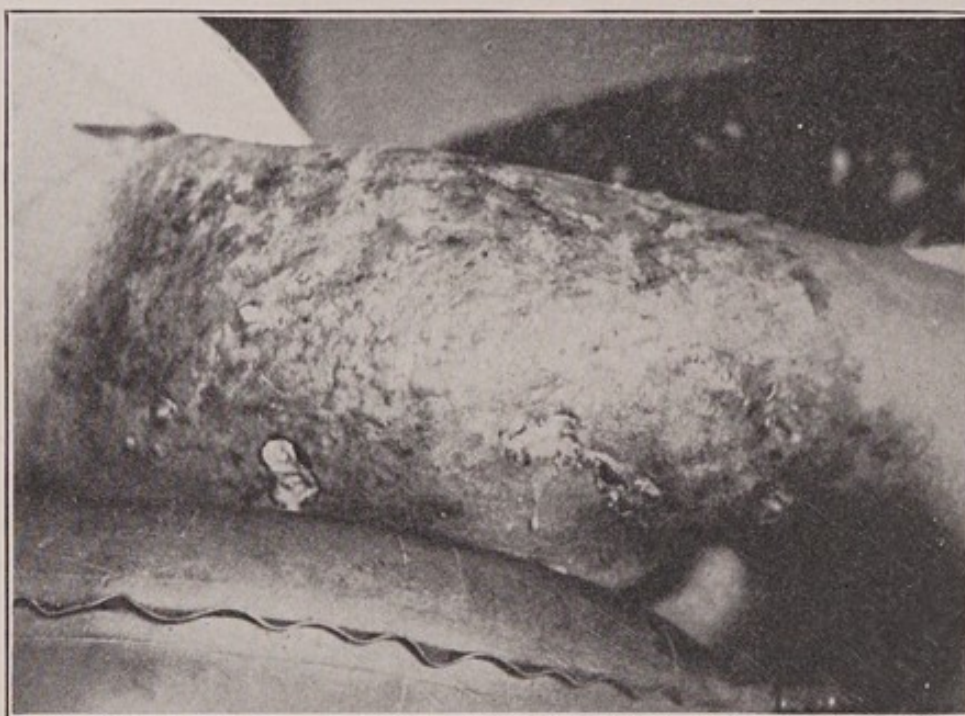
X-ray dermatitis of hip treated daily for one year by unskilled operator for tuberculosis of hip. Areas of malignant degeneration (Dr. H. G. Stover).
